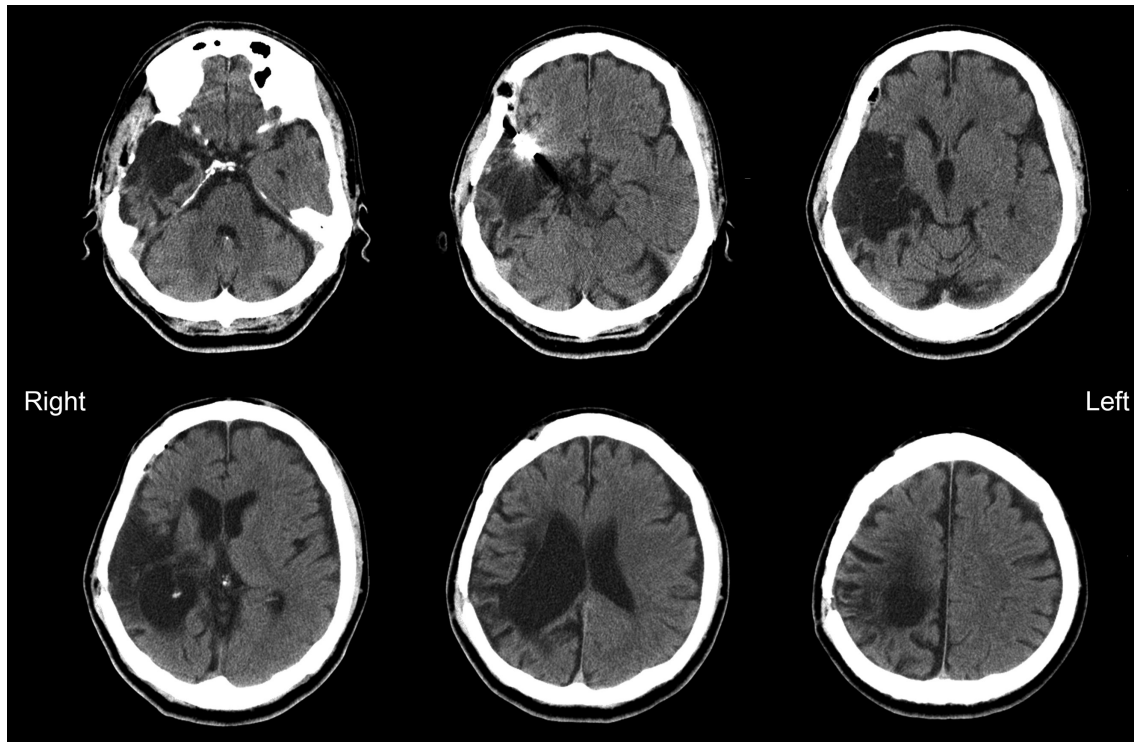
CT image of the patient's head. Low-density areas shown in the right temporal pole, superior and middle temporal gyrus, insula, supramarginal gyrus, angular gyrus, and medial superior occipital gyrus and their subcortical white matter, as well as in the posterior thalamus.
